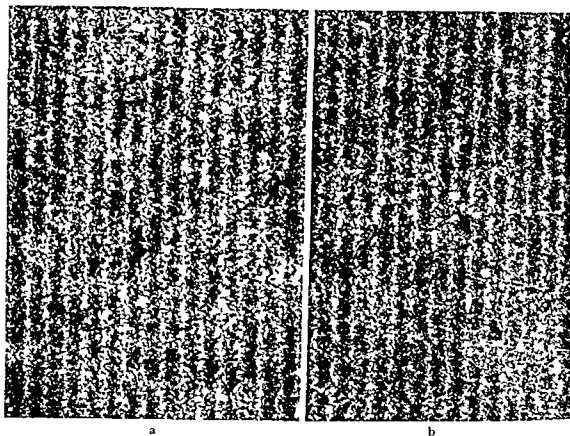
Roentgenograms of a grid utilizing high speed screens. The vacuum cassette (a) gives resolution superior to a standard cassette (b) but definition is not as good as seen in fig 7
